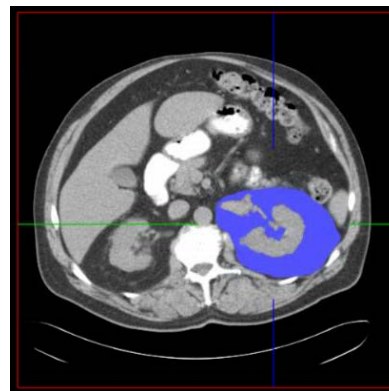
Vitrea LT 3D PAT measurement on axial CT image.
